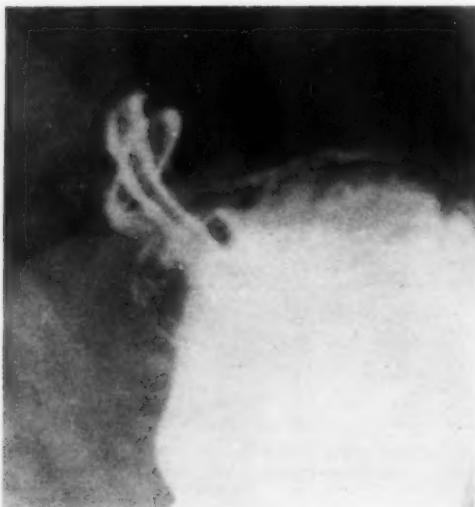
Case III. Jack-in-the-pulpit appearance of invagination of the esophagus in hiatus hernia. The rugae of the invaginated esophagus are clearly apparent through the veil-like coating of barium in the herniated stomach. Radiograph taken in the horizontal left posterior oblique position as the patient drew in the abdomen.
